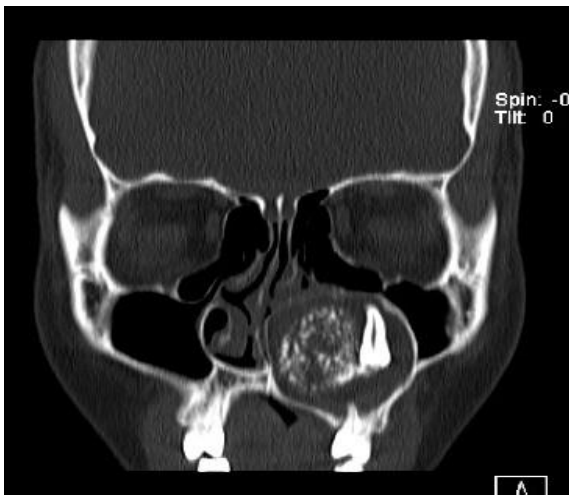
Coronal CT scan of the patient showing well circumscribed lytic lesion arising from the left maxilla with a discernible “floating” tooth with adjacent amorphous calcification in a round formation noted within the lesion.
